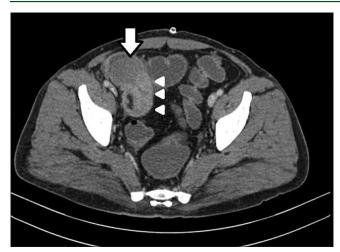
(Original): Contrast-enhanced CT images show a well-defined homogeneously enhancing mass (white arrow) at the leading edge of intussusceptum. Note that the typical bowel within the bowel configuration of intussception is also well-demonstrated (arrowheads)
